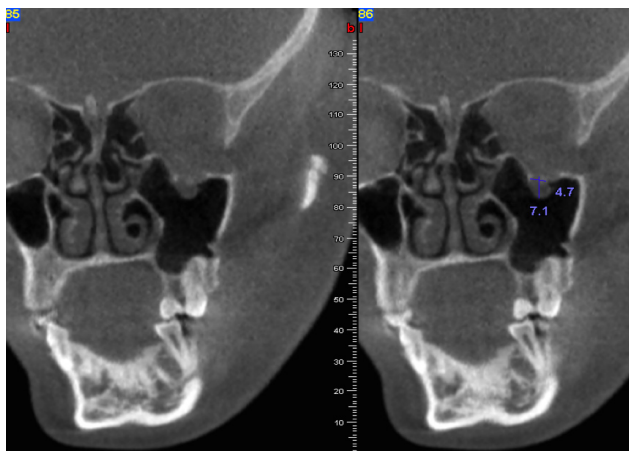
CBCT. Oblique coronal sections. Measurement of the herniated orbital soft tissue within the left maxillary sinus.
